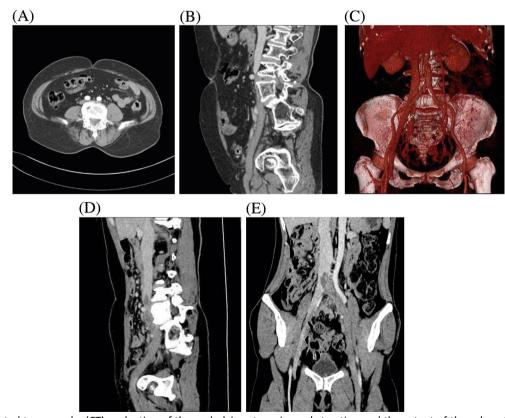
Computed tomography (CT) evaluation of the underlying stenosis or obstruction and the extent of thrombus. (A) Cross-sectional image demonstrates considerable compression of the left common iliac vein by the right common iliac artery. (B) Curved planar reformation along the left iliofemoral vein demonstrates extrinsic compression of the left common iliac vein between the right common iliac artery and the spine. (C) Volume-rendered image shows lack of visualization of the left iliofemoral vein. (D, E) CT images demonstrate stenosis of the left common iliac artery and the vertebral body, and thrombus extension to the inferior vena cava.
